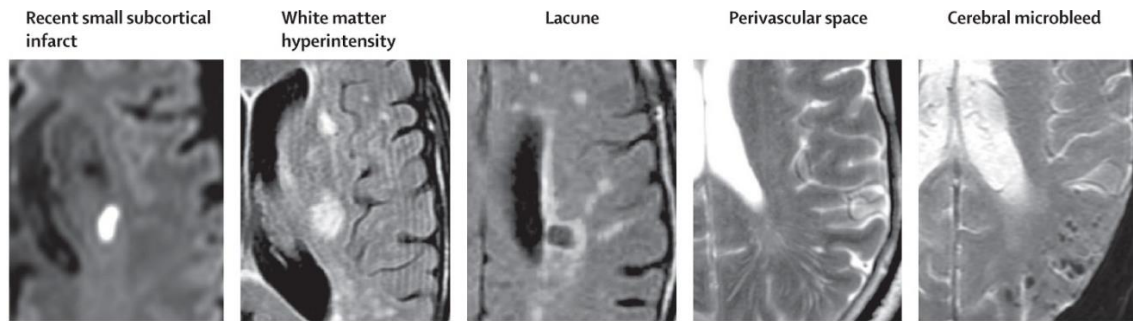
Examples of images from MRI findings for lesions related to VCI.
